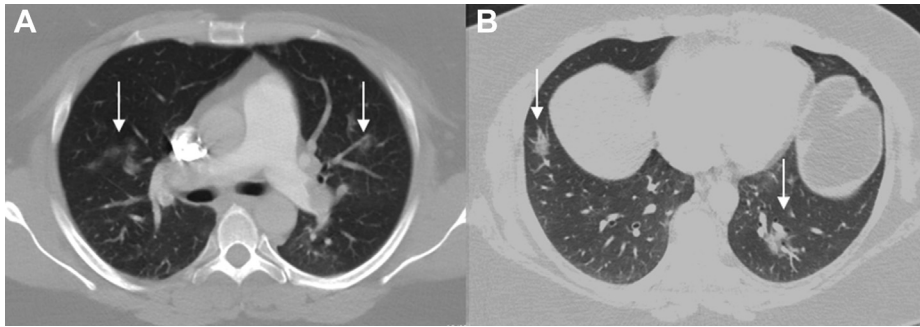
(A, B) Parenchymal windows of initial contrast-enhanced computed tomography scan showing bilateral interstitial ground-glass opacities (arrows).
